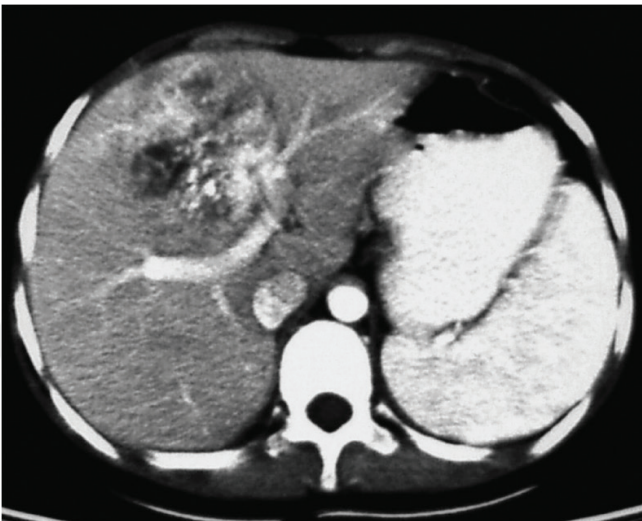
CT of hepatocellular carcinoma in pediatric patient.
